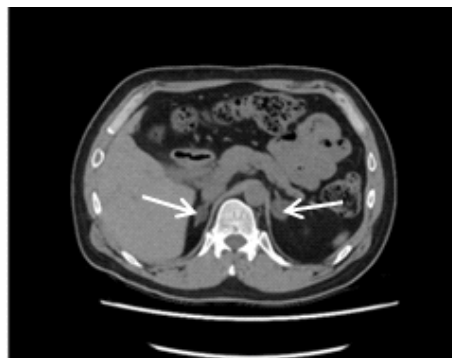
Axial CT Abdomen – Bilateral adrenal adenomas
